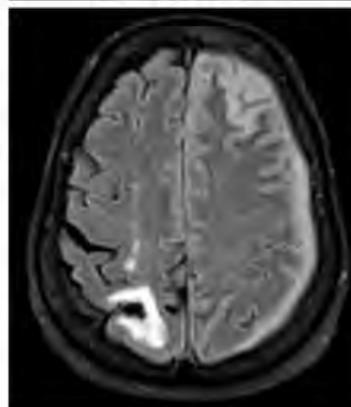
Axial T2 FLAIR image demonstrates a subdural fluid collection and cortical T2 hyperintensity in this patient with Pott's Puffy Tumor with underlying cerebritis who presented with seizures.
